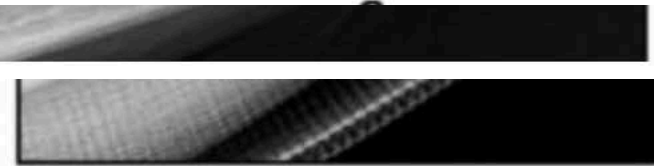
A) Anteroposterior view showing lateral condyle fracture (white arrow). B) Lateral radiograph showing lateral condyle fracture (white arrow).
